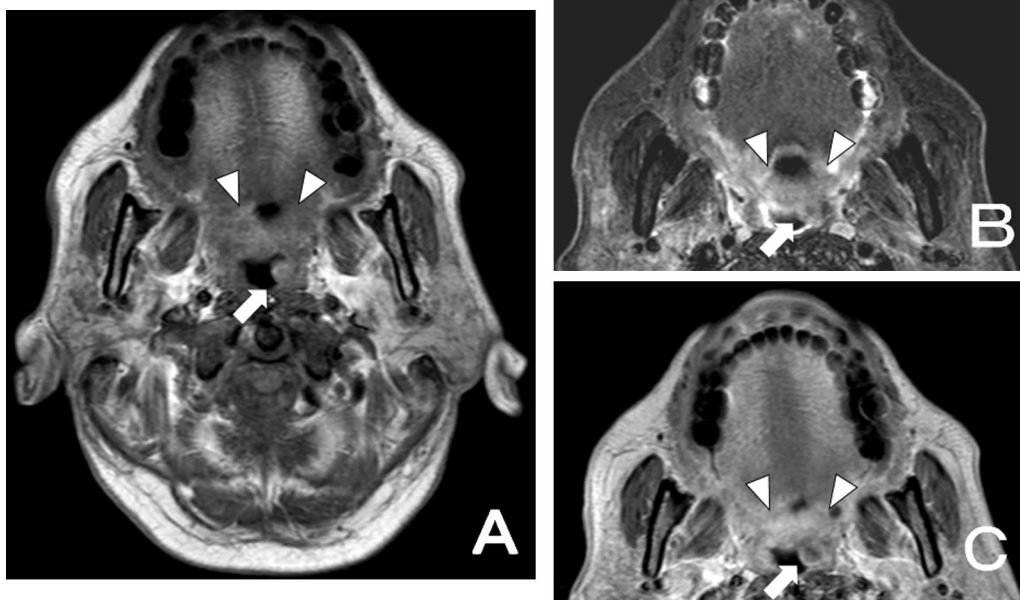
MRI images. The lesion spread from the soft palate to the pharynx, had similar signal intensity to the surrounding tissues (arrowhead), and a protuberance was observed in the left lateral wall of the oropharynx (arrow) (A: T1, B: T2, C: Contrast T1).
